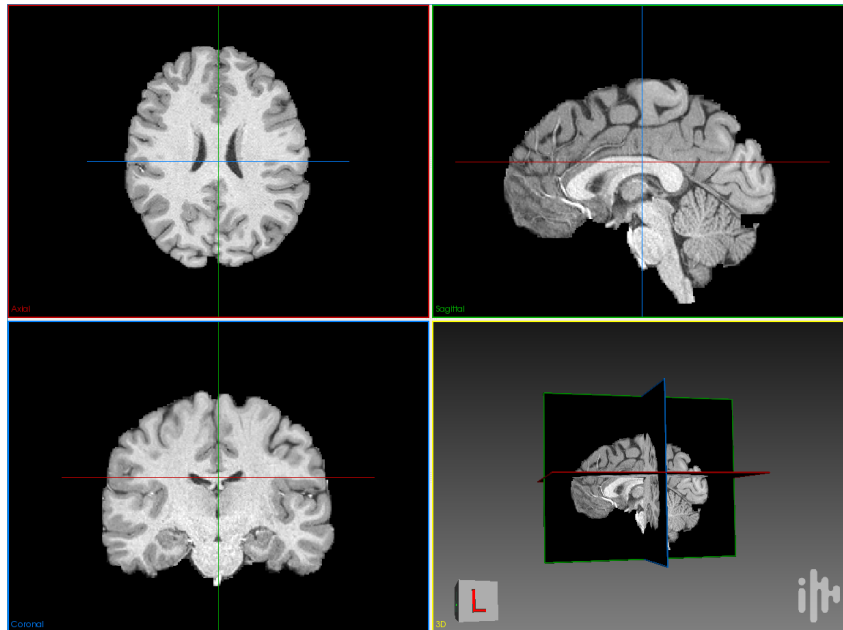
Example of a T1-weighted MRI visualized from three different planes (axial, sagittal, or coronal ) and as a 3D object. Software used: MI-Brain<sup>1</sup>
